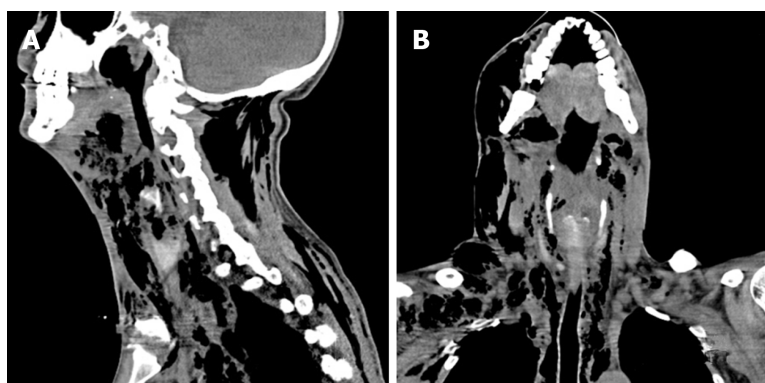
Sagittal and coronal computed tomography scans of the maxillofacial, neck and chest regions. Sagittal (A) and coronal (B) computed tomography scans of the maxillofacial, neck and chest regions showing extensive swelling and pneumatosis in soft tissues of bilateral oral, maxillofacial, temporal, cervical, parapharyngeal space, mediastinum, chest and back regions.
